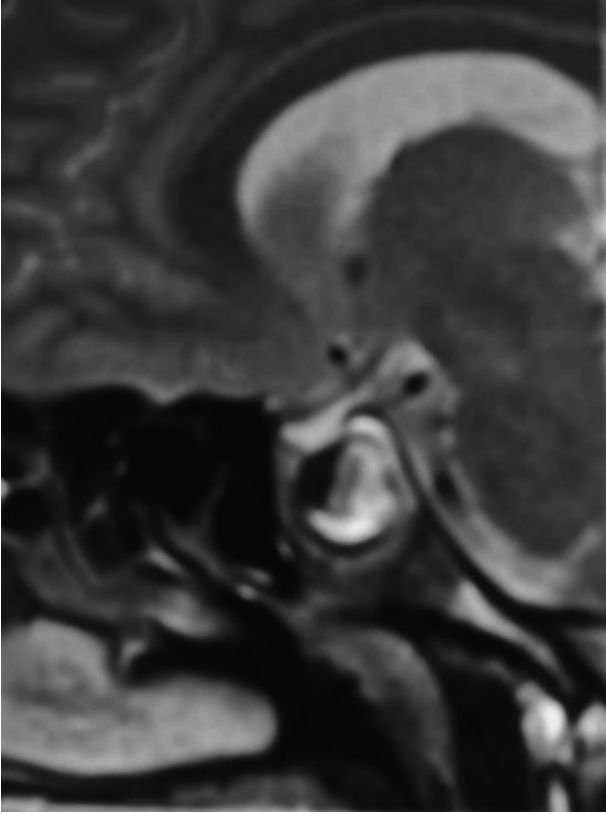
MRI of the brain shows non-enhancing mixed intensities haemorrhagic and cystic areas in the pituitary gland.
